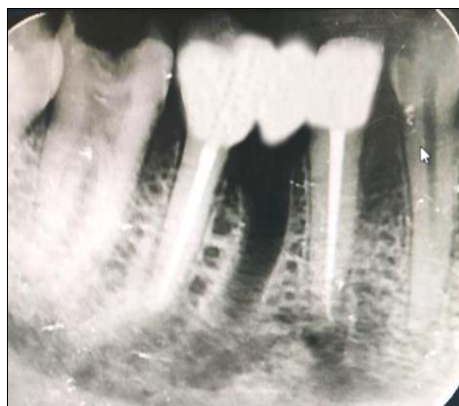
Post-operative radiographic picture with Fixed Dental Prosthetic.
